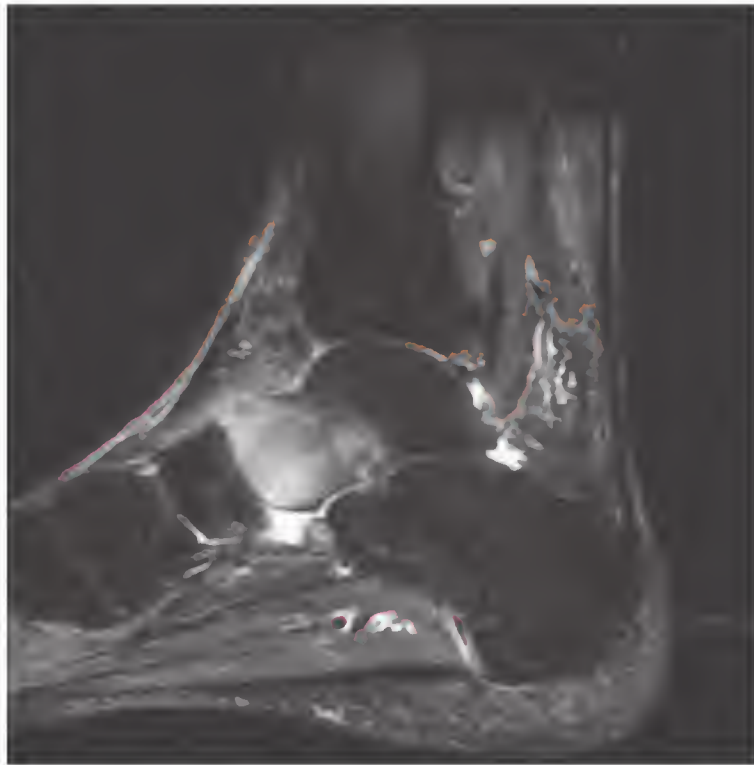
Sagittal proton-density magnetic resonance image of the ankle demonstrating marked marrow signal change within the head of the talus. Differential considerations include fracture and osteonecrosis. The follow-up plain radiograph for this patient indicated avascular necrosis. (Courtesy Christopher G. Roth, MD.)
